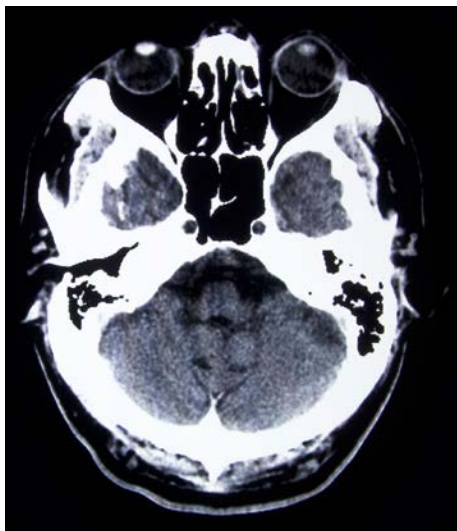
Lower brain axial CT image.
